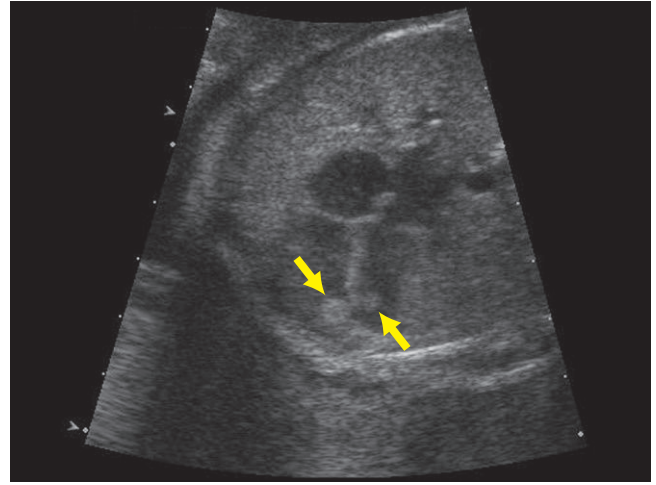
In utero fetal ultrasound demonstrating multiple echogenic masses (arrows) both within the right and the left ventricle of the heart corresponding to multiple cardiac rhabdomyomas.
